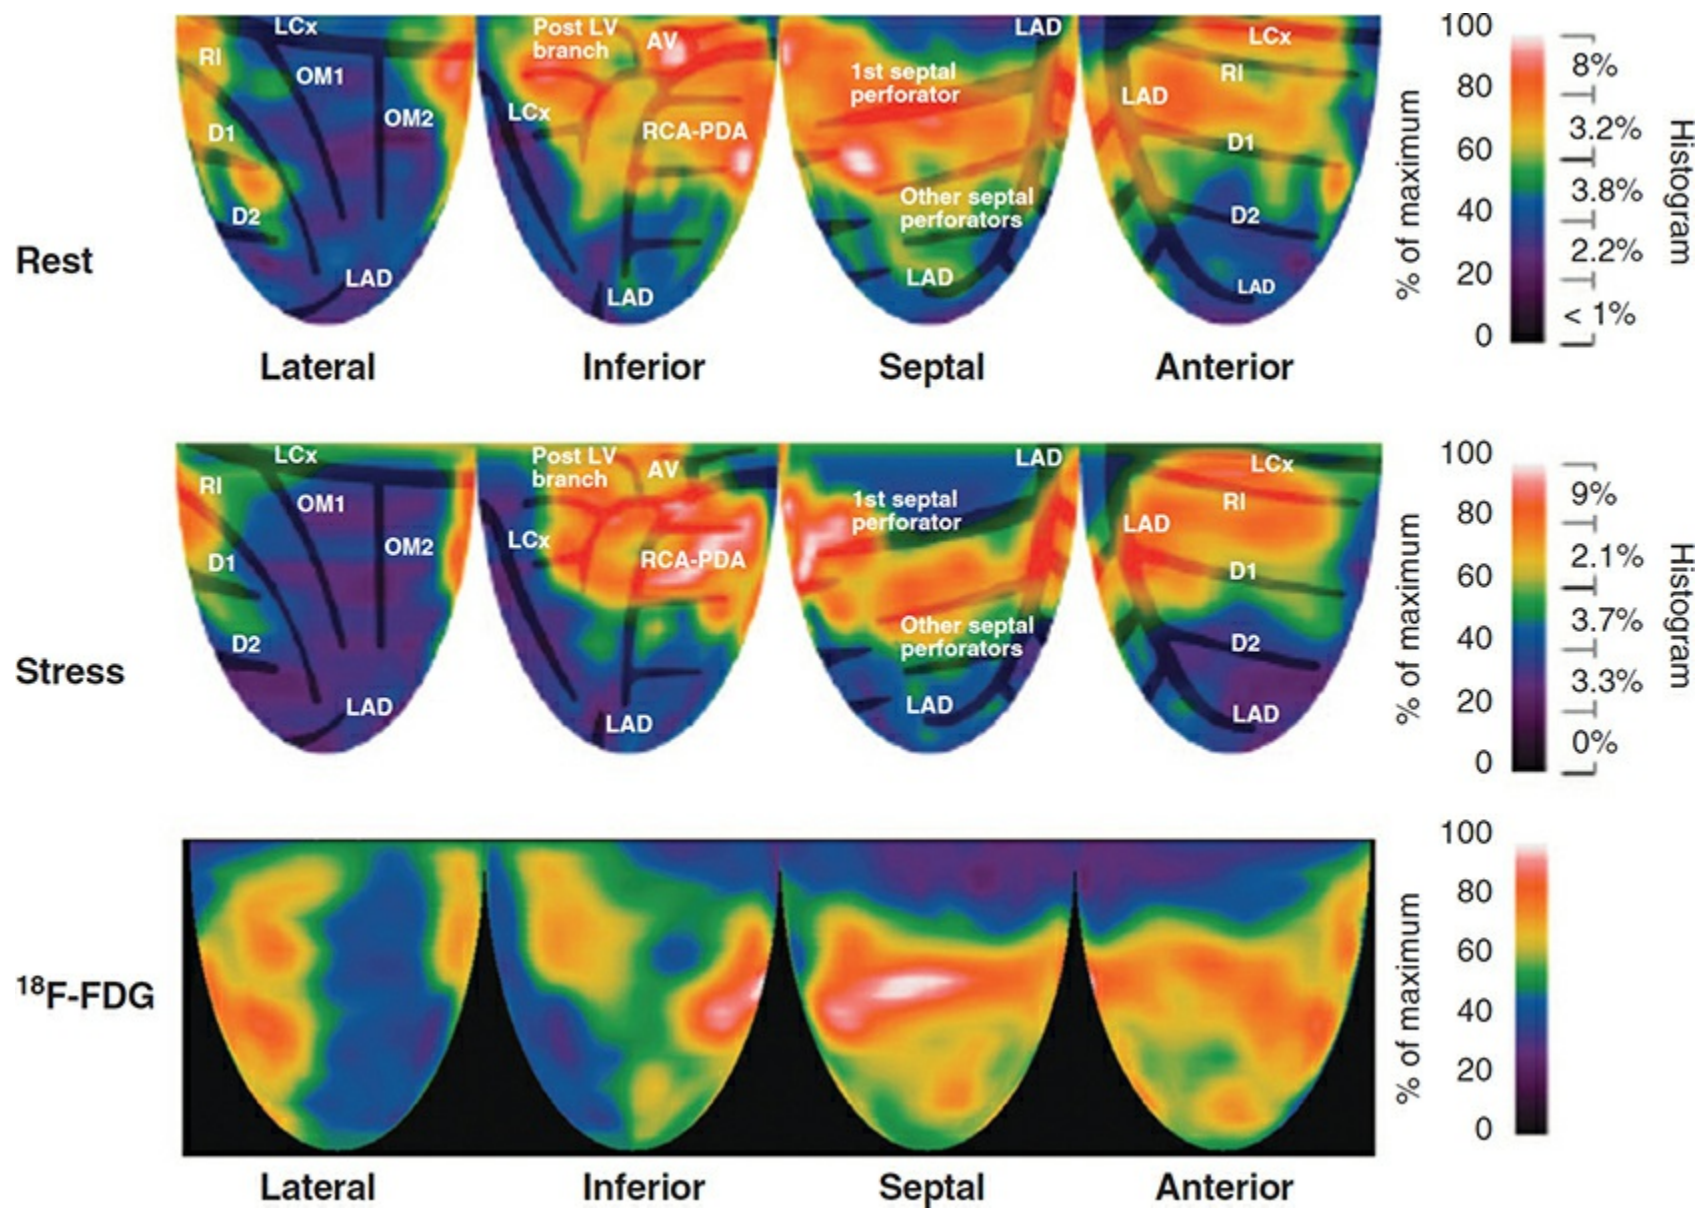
Relative rest and stress myocardial perfusion and ^{18}F -FDG images are color coded by the scale for relative myocardial uptake. For the rest stress relative perfusion images, the histogram on the right side of the color bar scale gives the relative activity as percent of maximum (100%) and percent of the left ventricle in each range of relative perfusion.
